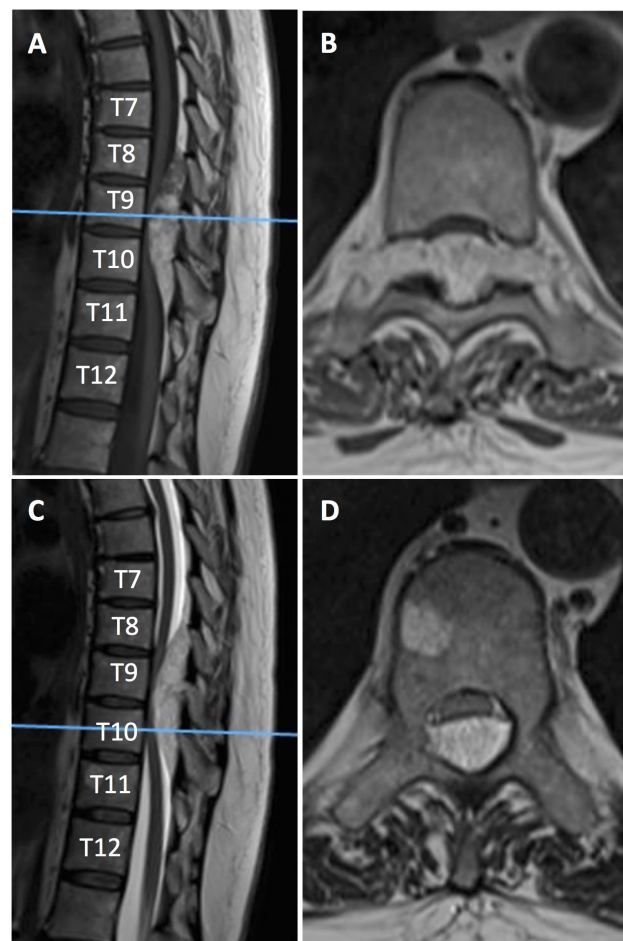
Magnetic resonance image showing an epidural lesion extending from T8 – T10. Sagittal (A) and axial (B) T1-weighted images showing the dumbbell-shaped hyperintense lesion extending multiple levels and through the foramen at T9/T10. Additionally, the lesion shows hypointense regions, corresponding to the vascular component of the tumor. Sagittal (C) and axial (D) T2-weighted images showing severe spinal stenosis with spinal cord compression.
